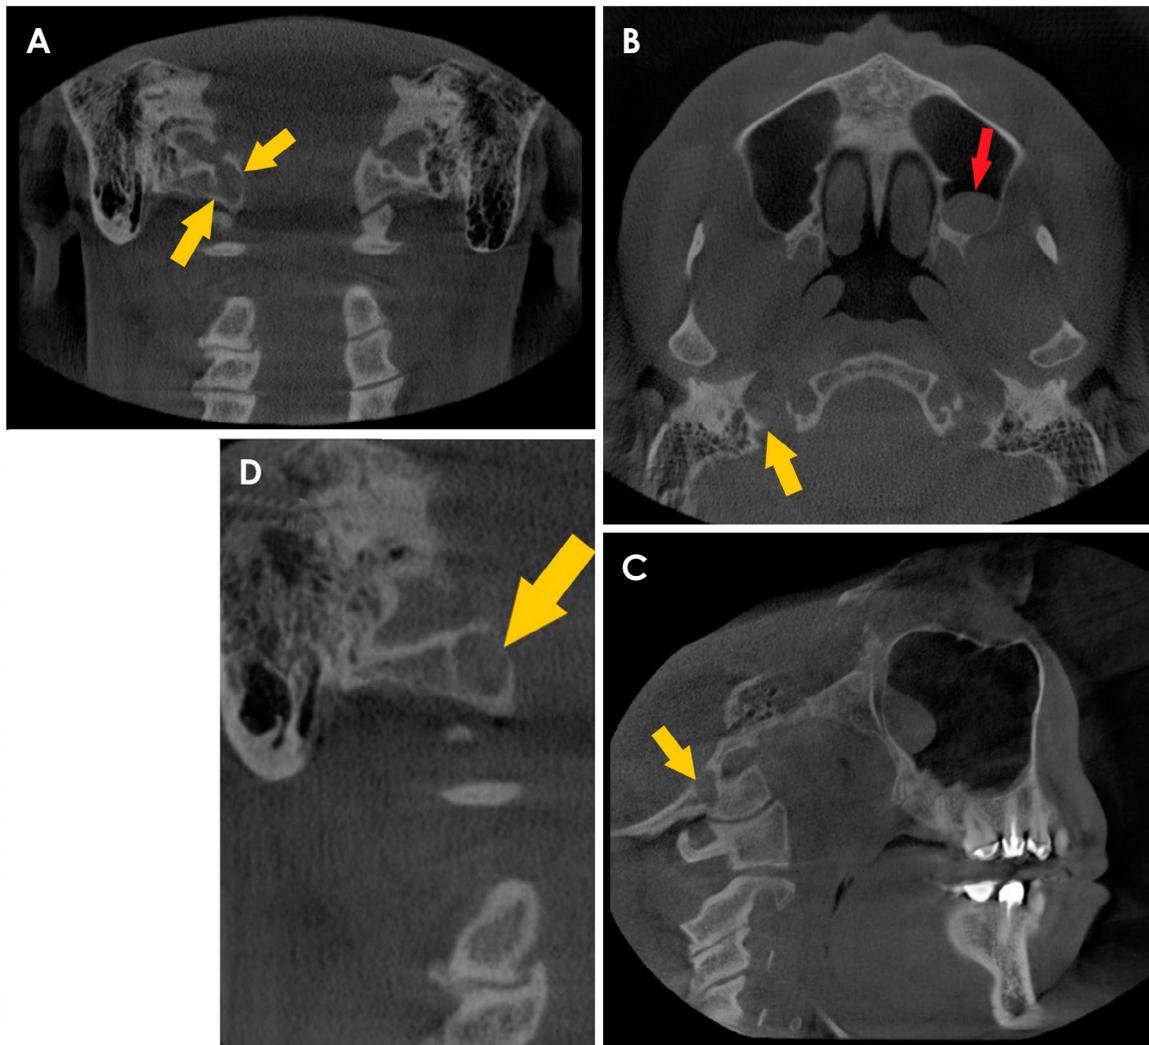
A. A coronal cone-beam computed tomographic (CBCT) image demonstrates extension of the right jugular bulb into the ipsilateral occipital condyle. B. An axial CBCT image depicts maintenance of the jugular spine (large arrow) and a mucus retention pseudocyst in the left maxillary sinus as an incidental finding (small arrow). C. A sagittal CBCT image shows irregular expansion of the jugular bulb into the occipital condyle. D. A sagittal CBCT image indicates a dilated jugular bulb.
